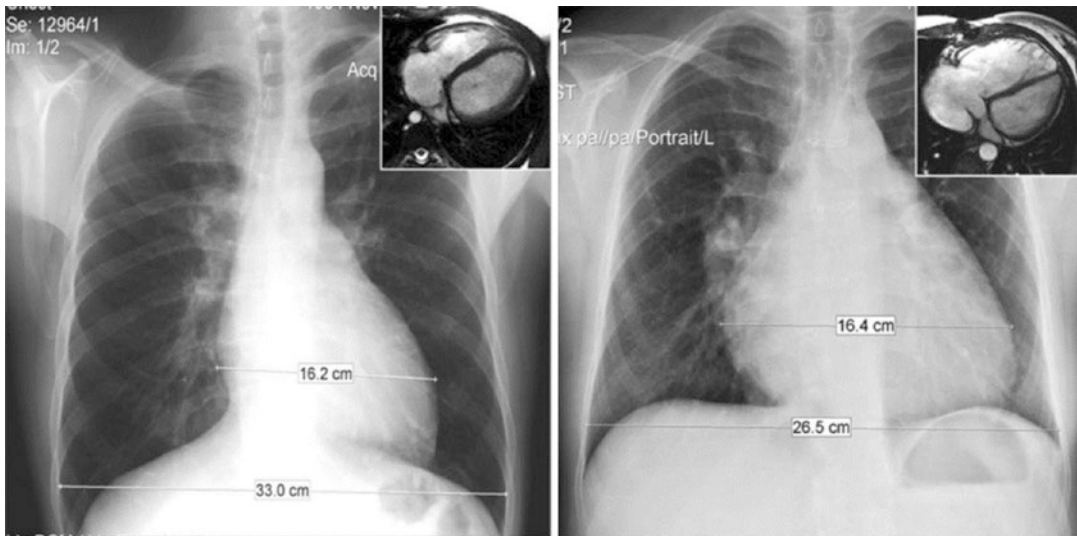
Chest X-ray and magnetic resonance imaging (MRI inserts) from two patients 20 years following repair of Tetralogy of Fallot. Both patients were treated with a pulmonary artery patch and did not have pulmonary artery stenosis. The patient on the left had restrictive physiology on the RV and there was only a mild increase in RV size.
